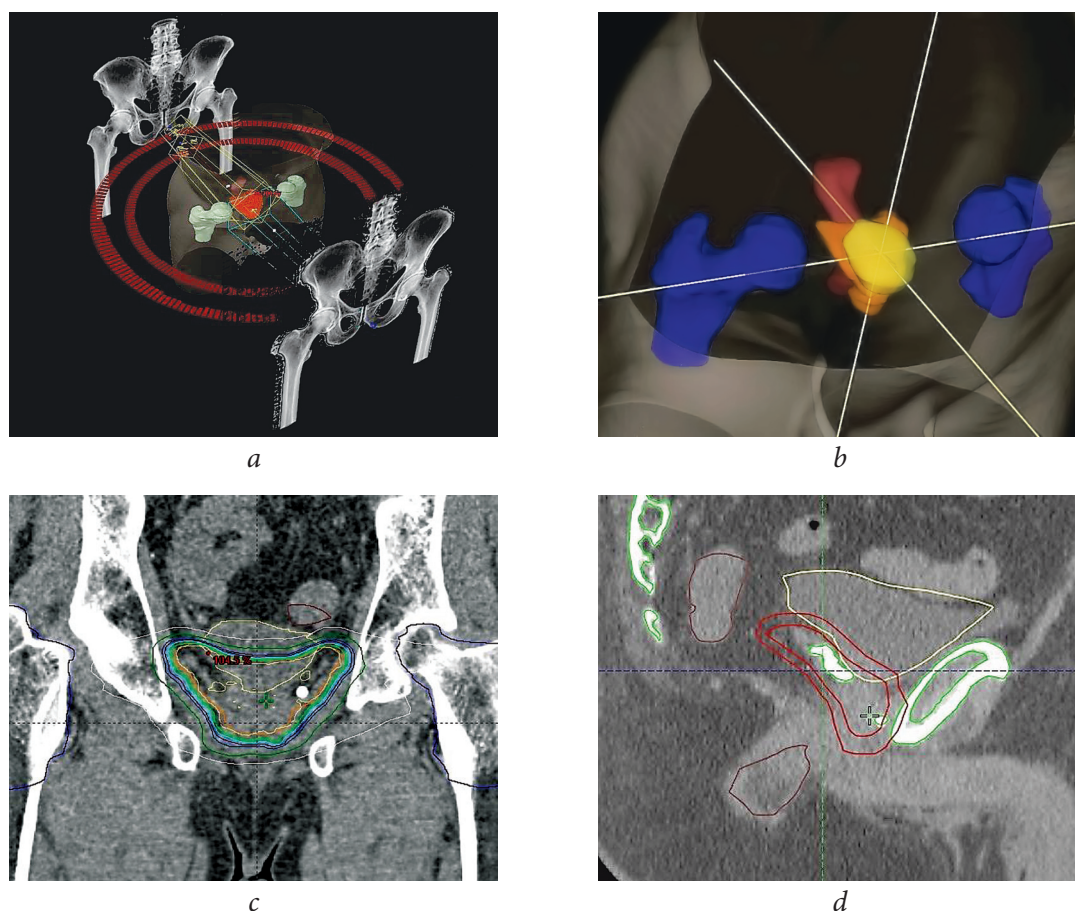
Dosimetric support of the stereotactic radiotherapy on the prostate bed: *a* — example of a 3D model of a treatment plan using two dynamic arches (RapidArc); *b* — 3D model of irradiated prostate bed (orange) and organs at risk: bladder (yellow), rectum (dark red), femur heads (blue); *c* — an example of isodose distribution (coronal scan), to the left of the vesico-urethral anastomosis is visible X-ray contrast gold seed; *d* — clinical and planned target volumes (sagittal scan), x-rays of contrast staples used as landmarks are visible in the area of the prostate bed
